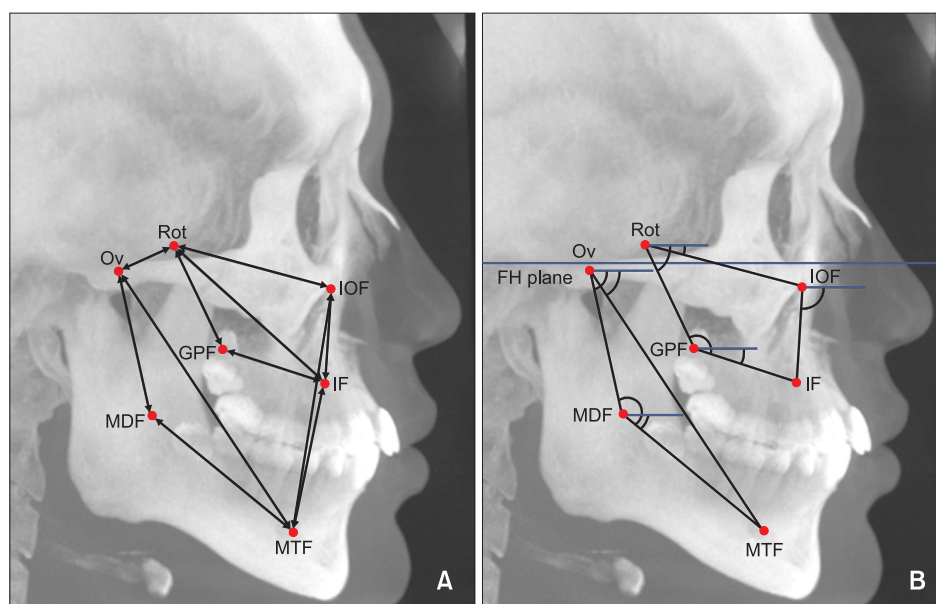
Linear (A) and angular (B) parameters in cone-beam computed tomography (CBCT) images. Identification of the landmark and measurements were performed three-dimensionally. To visualize the location of the landmarks and measurement parameters, they were simply drawn in the lateral maximum projection image of CBCT. FH, Frankfort horizontal plane. See Table 2 for definition of each landmark.
